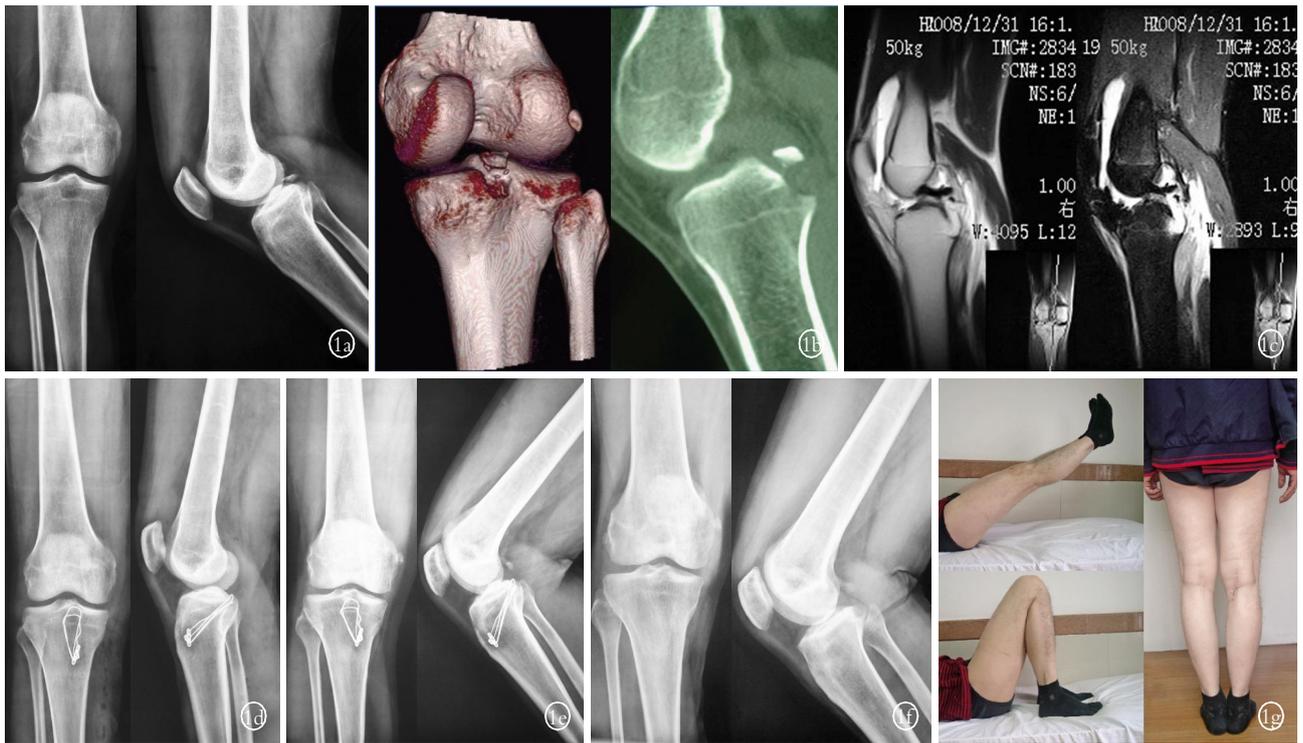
男, 37 岁, 膝关节外伤后疼痛, 伸直受限, 体检后抽屉试验阳性 1a-1c. 术前正侧位 X 线片 (1a)、CT (1b)、MR (1c) 示后交叉韧带胫骨止点撕脱骨折, 骨折块向上方移位 1d. 术后 X 线片示骨折复位满意 1e. 术后 3 个月骨折愈合 1f. 术后 4 个月拆除钢丝 1g. 术后 3 个月患膝关节活动良好
